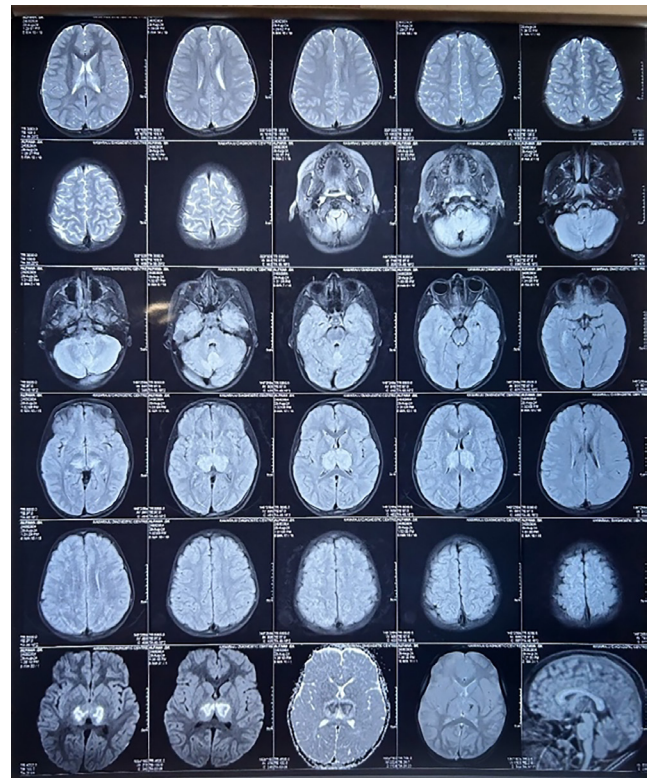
Areas of altered signal in thalami, cerebellar vermis, paravermian cerebellar hemisphere, right hippocampus, and left paraventricular region showing T2, FLAIR hyperintensity, T1 hypointensity with areas of diffusion restriction
